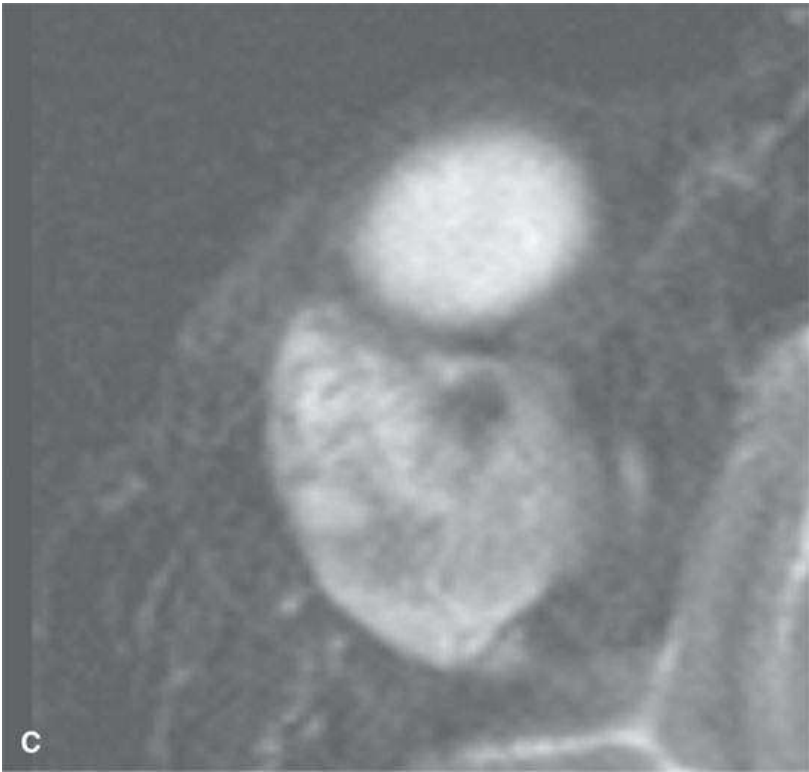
Adenoid cystic carcinoma of the lacrimal gland with possible calcification in impacted mucoïd material or dystrophic calcification. The nature of the signal void is less clear on the contrast-enhanced T1-weighted magnetic resonance imaging (MRI) in (B) and the T2-weighted MRI in (C). In this case, the presence of a calcification adds nothing to the diagnostic process.
